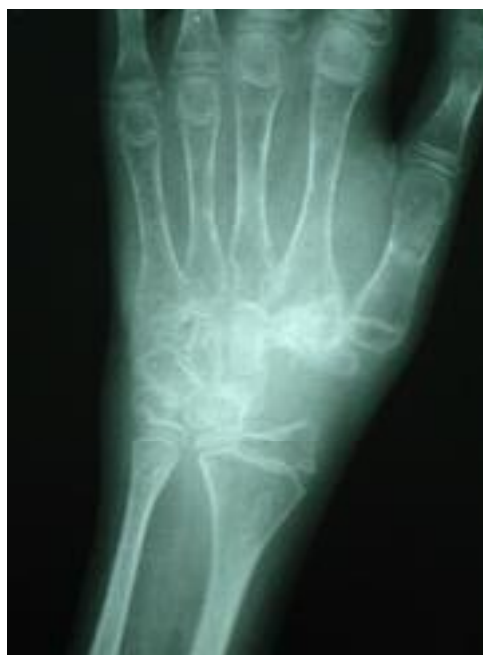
Anteroposterior X-ray of the left wrist three months post surgery
